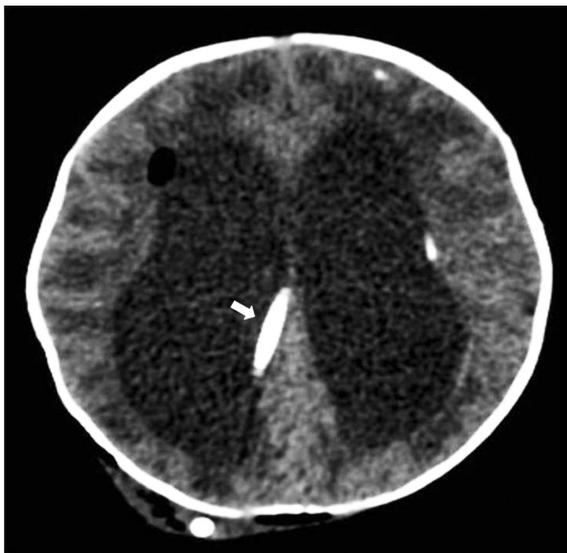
Ventricular catheter (white arrow) is seen in the right ventricle on axial CT image.
